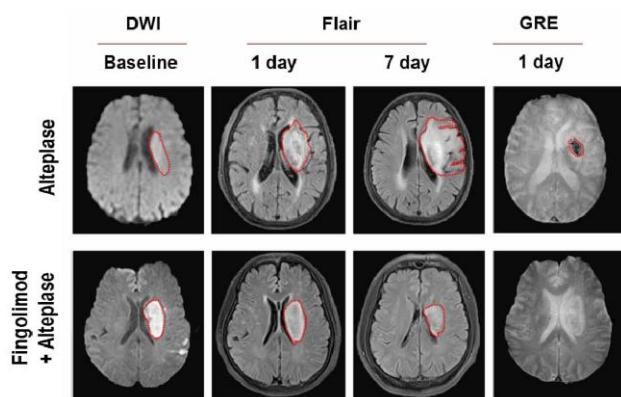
MRI comparison of infarct volume, edema around the infarct and hemorrhagic transformation
